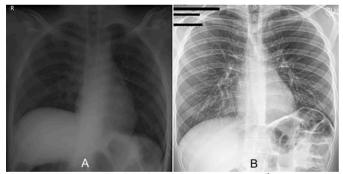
Postoperative imaging. (A) Postoperative 1st day, portable chest x-ray showing reduced left diaphragm. (B) Postoperative 1st year, standard chest x-ray, showing reduced left diaphragm.
